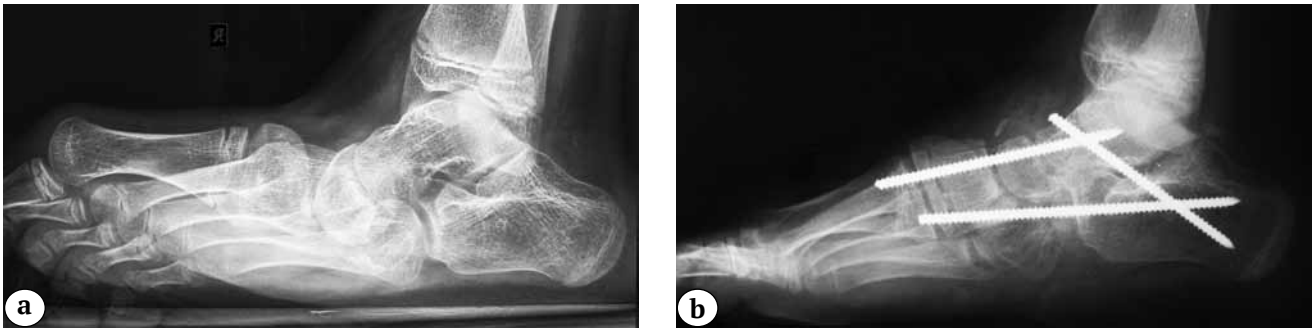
X-ray images of patient 13 y.o.:
